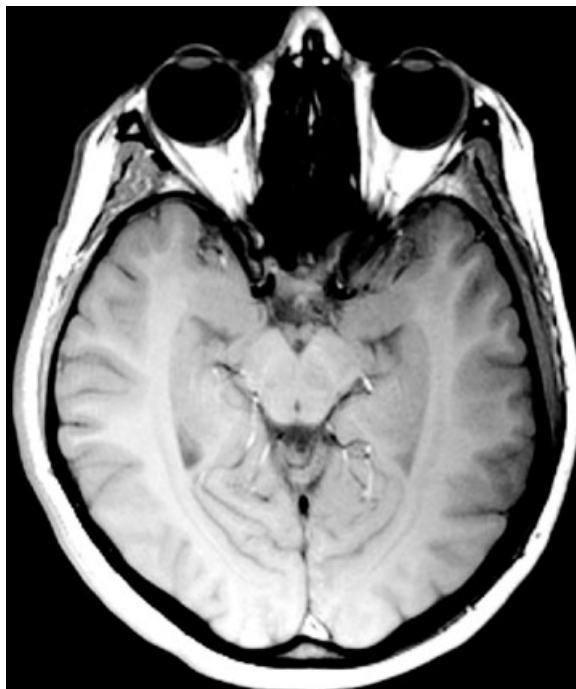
A head section across the ocular globes, obtained using a magnetic resonance imager
